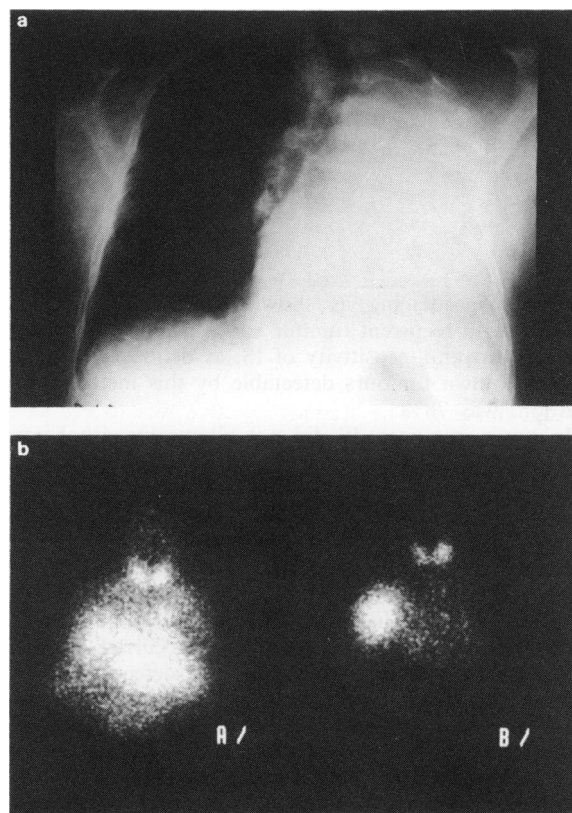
Recurrence 18 months after left pneumectomy for lung carcinoma. a, Chest X-ray, anterior view. No tumour evidenced in the right upper lobe by this technique. b, Immunoscintigraphy (IS), anterior view: 3 days (A/) and 6 days (B/) after i.v. injection of radiolabelled Po66. A complete disappearance of blood activity between day 3 and day 6 was observed whereas tumour labelling remained elevated. Note the uptake of ¹³¹I by thyroid gland.
